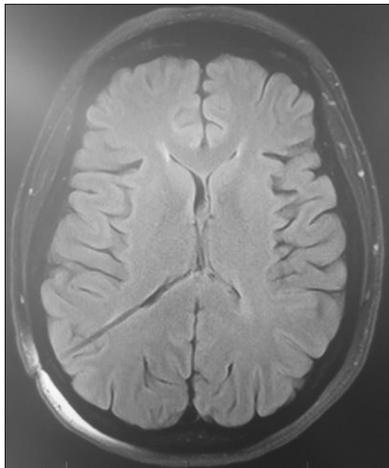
Preshunt adjustment axial T1 MRI demonstrating slit ventricles suggestive of shunt overdrainage.
